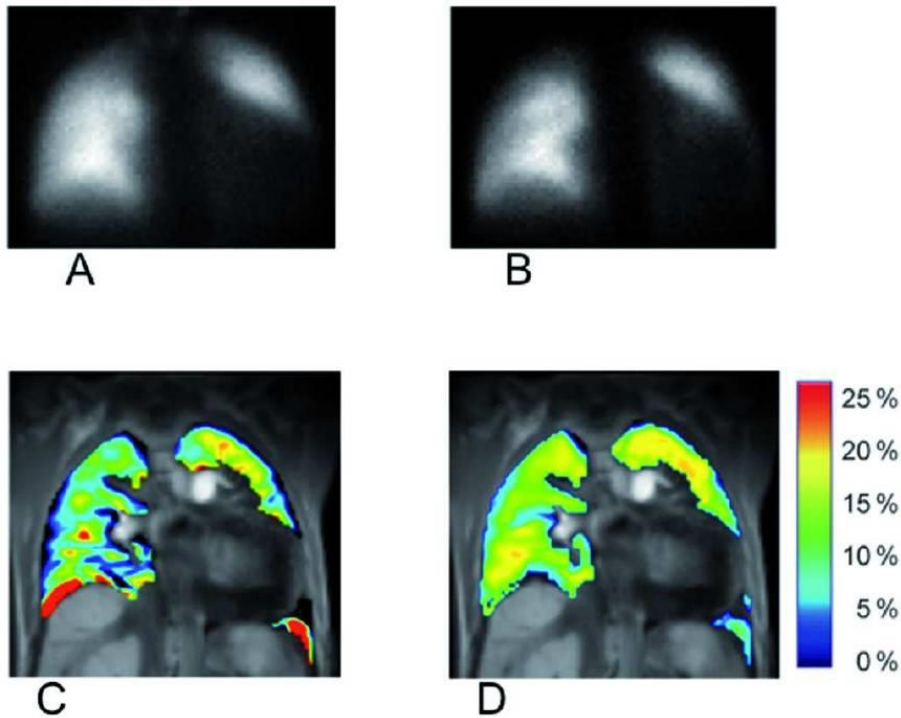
46-year-old female patient with lowered SI in the left lung dependent on either an enlarged heart or a combined ventilation perfusion defect. A: Ventilation scintigraphy with lowered signal in the left lower lung. B: Perfusion scintigraphy with lowered signal in the left lower lung. C: With the morphologic information of the RSE map, the observed lower signal is identified as an enlarged heart. D: The morphologic information of the CCC map also allows the identification of the enlarged heart.
